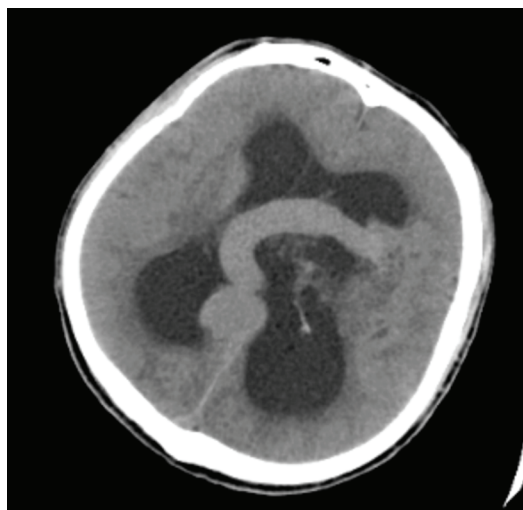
Cerebral arteriovenous malformation: Axial cranial CT image shows vein of Galen aneurysmal malformation with dilated lateral ventricles
